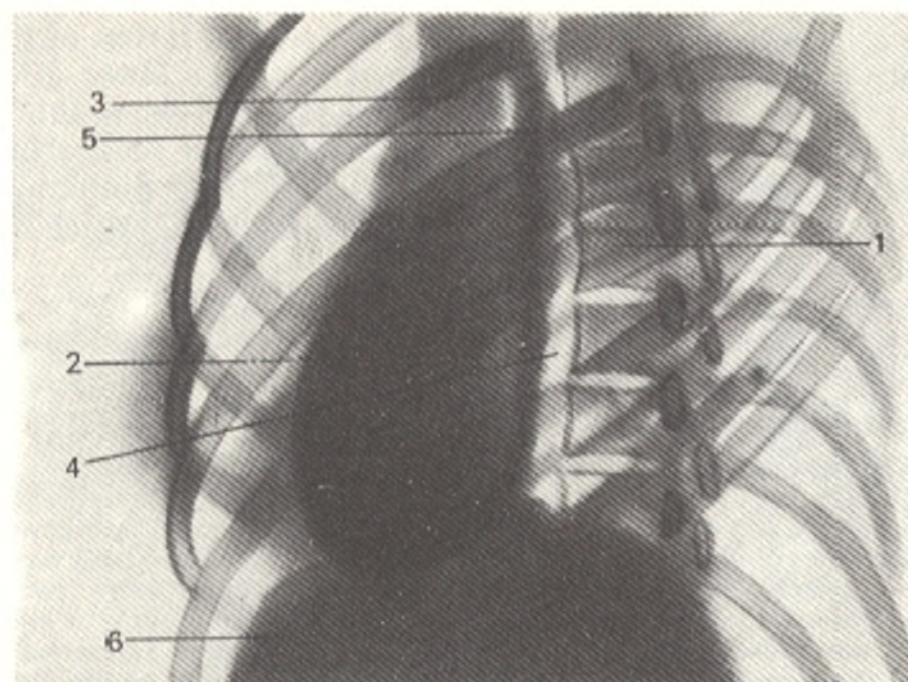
Lateral view radiograph of the oesophagus.
